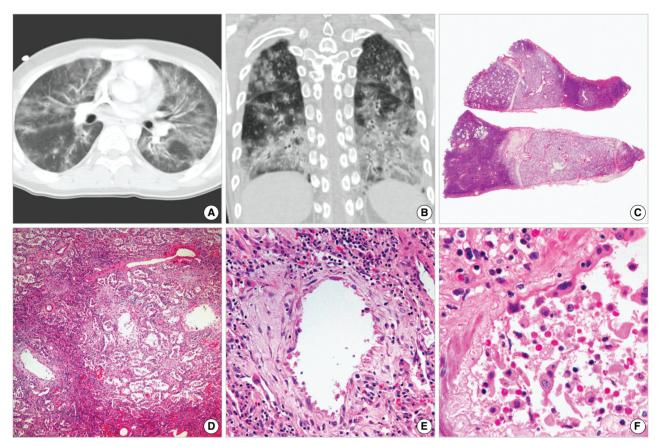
(A) and (B) Chest CT image showing bilateral ground-glass opacity along bronchovascular bundles with bronchial dilatation. (C) Scanning power view image showing an airway-centered lesion. (D) Bronchial wall thickening due to fibroblast proliferation and diffuse interstitial widening due to lymphocytic infiltration. (E) and (F) Epithelial sloughing or totally epithelial loss in bronchioles associated with the proliferation of subepithelial fibroblasts.
